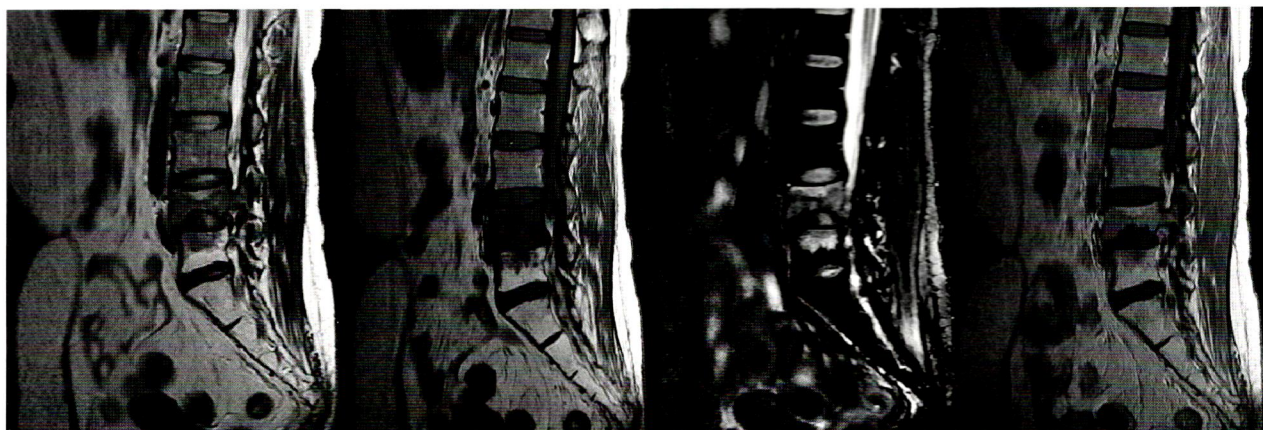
MRI lumbosacral spine (T2, T1, T1FS and T1+C) was done at 2 months later. Evidence of lower L4 end plate irregularity and L4+L5 destruction with adjacent left paravertebral mass were suggestive of liquefied abscess in the left psoas muscle. Infectious process was considered. Spine metastasis with necrotic tumor was in the differential diagnosis. The patient underwent fluoro-guided biopsy which proved to be metastasis SCCA.
